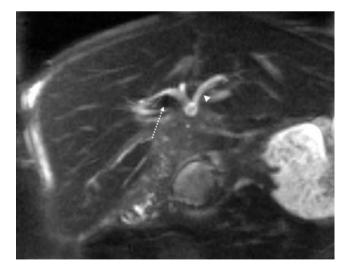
Coronal MRI section corresponding in position to the PTC. *Dashed arrow* points to the umbilical portion of the left portal vein and *arrowhead* to the left lateral sectional duct. Note again the bowing of the right hepatic duct as it curls around the vein. This was not appreciated before the reconstruction was performed.
